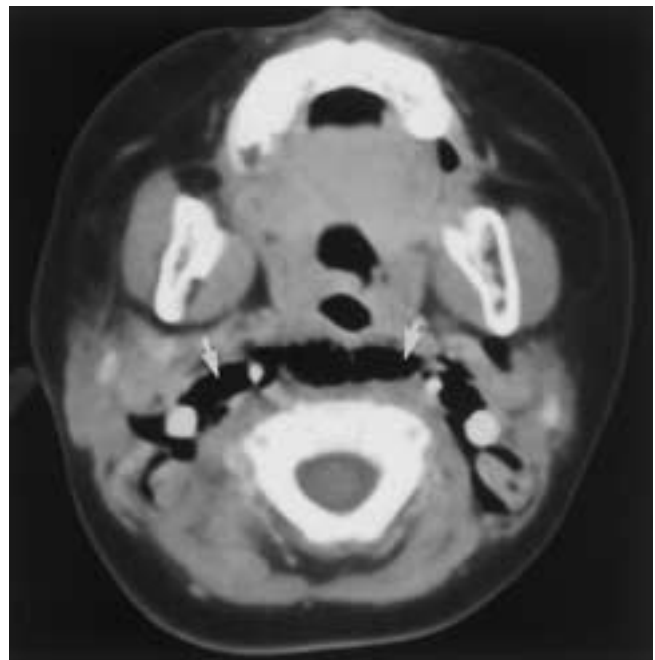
Penetrating injury in a 4-year-old boy who fell with a sharp stick in his mouth, puncturing his pharynx. Axial contrast-enhanced CT demonstrates extensive extraluminal air (*arrows*).
